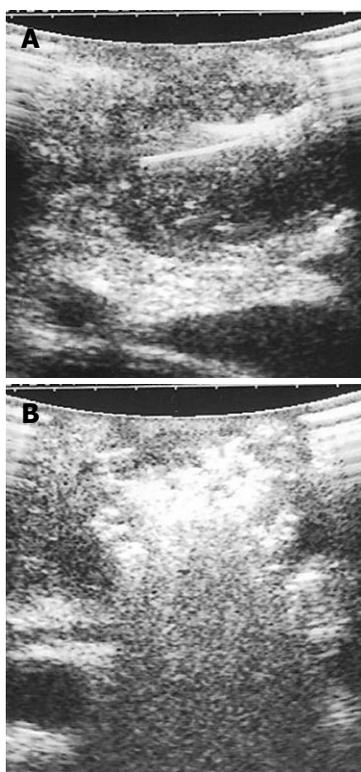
Intraoperative ultrasound monitoring. A: Needle with expandable electrodes is opened in the pancreatic hypoechoic mass under intraoperative ultrasound guidance; B: During radiofrequency ablation, the ablation zone becomes hyperechoic.
